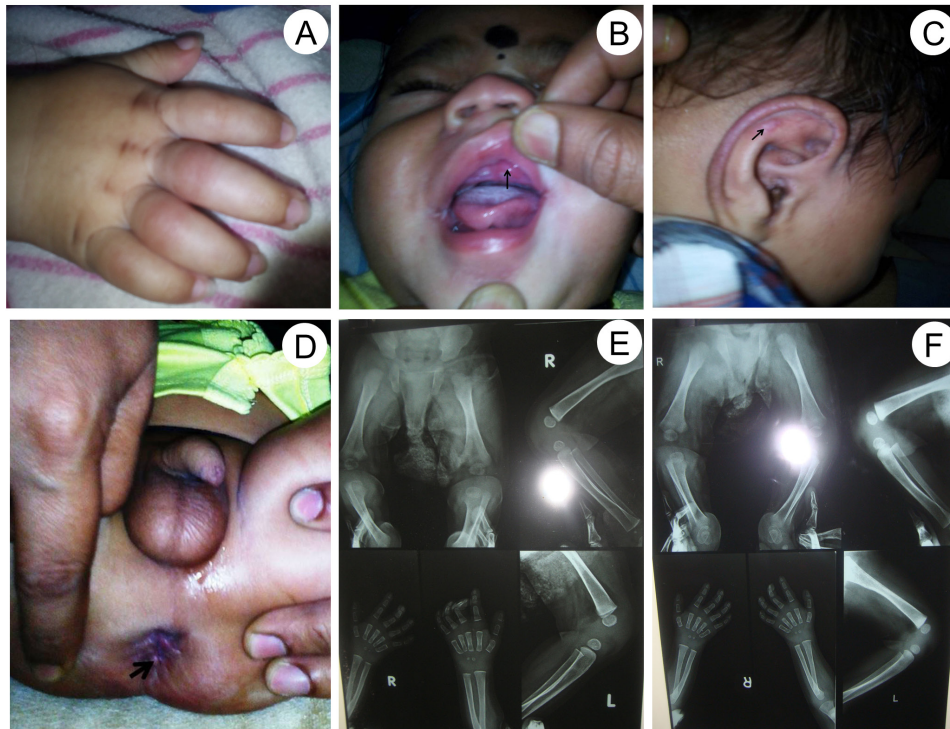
Images of different regions affected in infantile hyalinosi in identical twins. (A) showing Progression of joint contractures in the hand; (B) showing Gingival hypertrophy (Arrow mark); (C) showing Reddishness and papule over earlobe (Arrow mark); (D) showing Papular nodules in the perianal region (Arrow mark); (E) & (F) radiographs showing the joint contracture.
